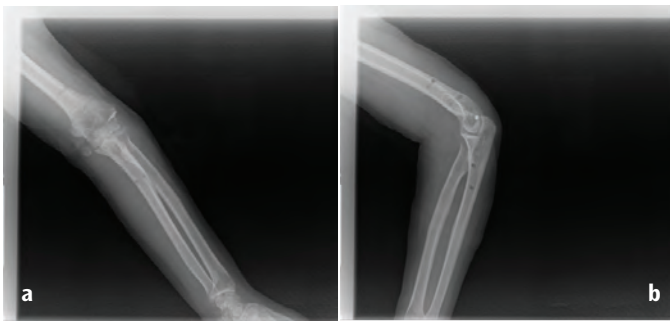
a, b) Full bone union was observed radiographically in all the patients
